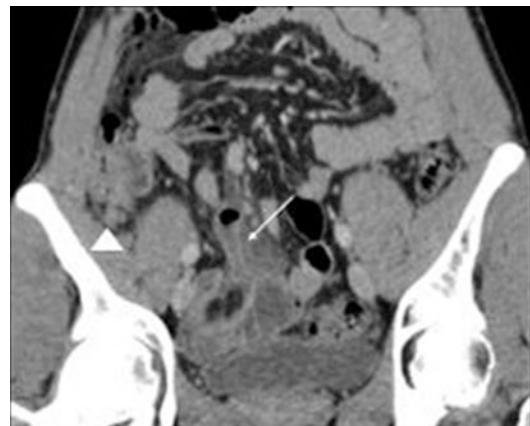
Meckel's diverticulitis in a 25-year-old man with right lower quadrant pain. Coronal abdominal/pelvic CT image shows a blind-ending dilated tubular structure arising from the antimesenteric border of the ileum in the right lower quadrant, with trace surrounding fluid and fat stranding, representing an inflamed Meckel's diverticulum (arrow). Note the presence of a normal appendix adjacent to the cecum (arrowhead)
